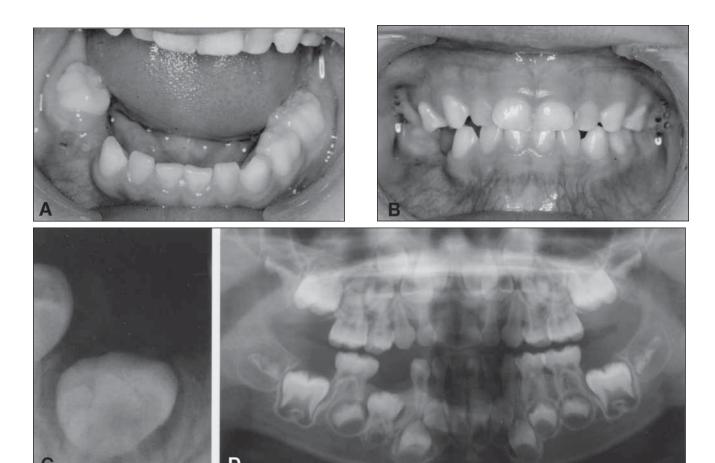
Clinical intraoral views (a, b) and radiographic appearance (c, d) at 5 years, 3 months old before treatment.
